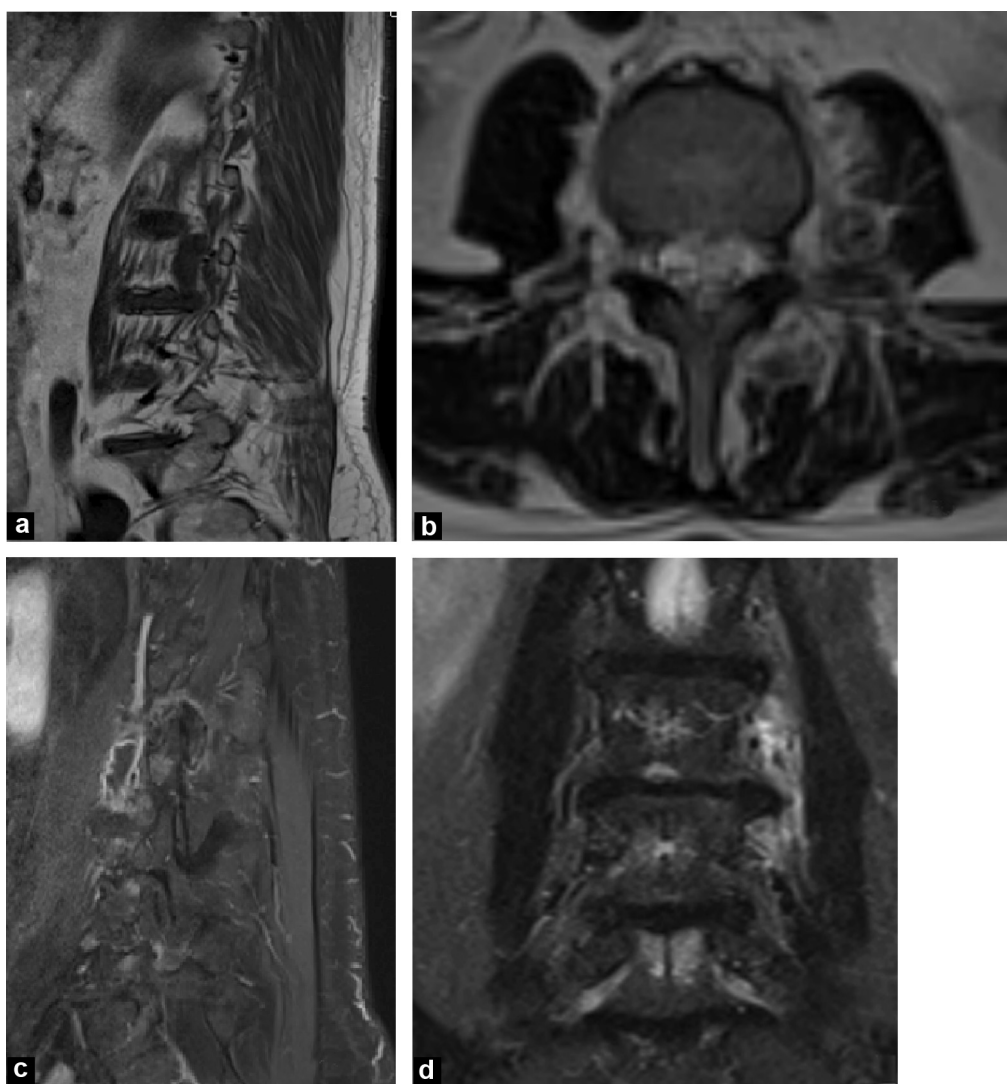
MRI without and with injection of gadolinium.
